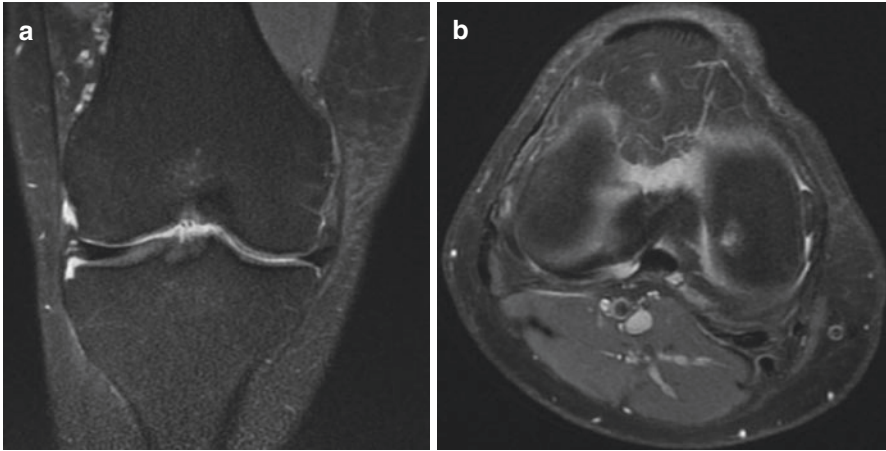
Coronal (a) and axial (b) MRI views of a superiorly displaced flap tear of the medial meniscus
